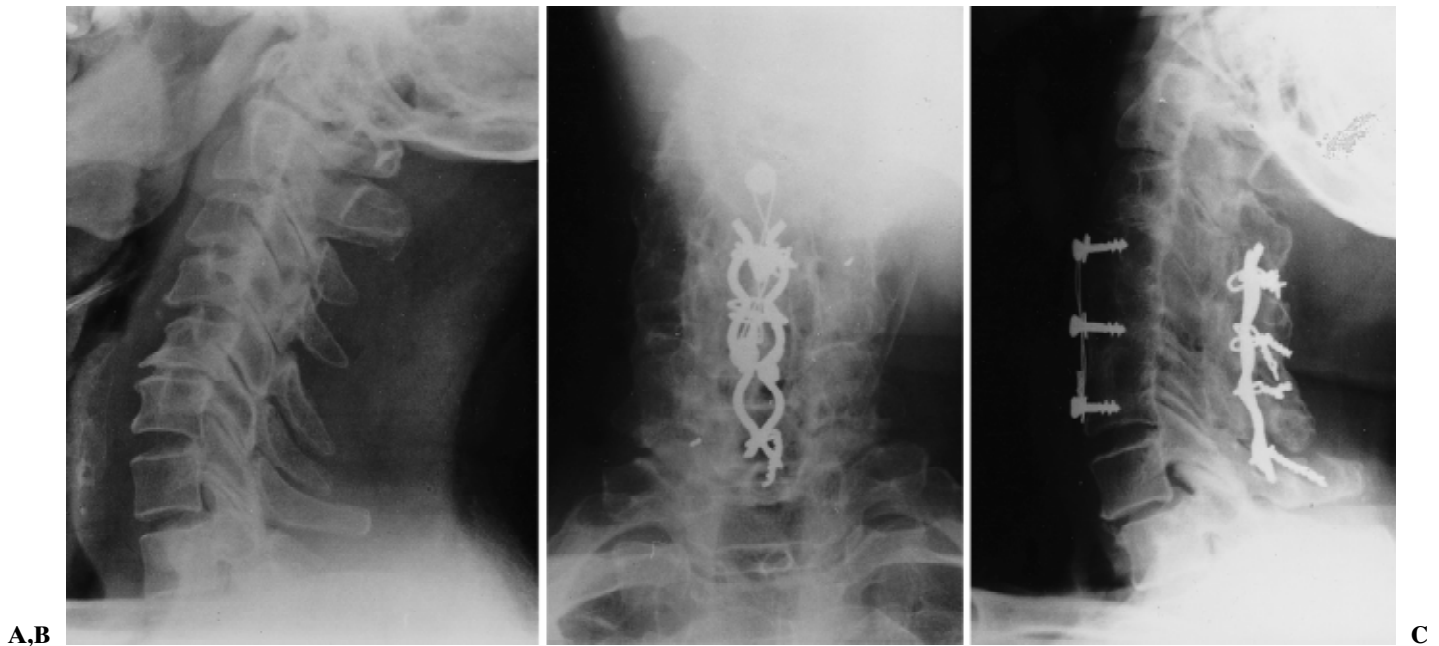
Roentgenograms of case 1. A Lateral radiograph before surgery, showing malalignment, deformity of vertebral body, and posterior spurs between C4 and C6. B Anteroposterior and C lateral radiographs made 15 years
